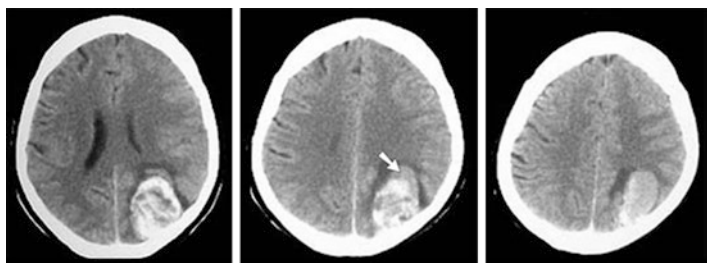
Non-contrast CT scan showing left parietal intracerebral hemorrhage into a tumor. Note the different density (white arrow) and the surrounding low density which represents edema
